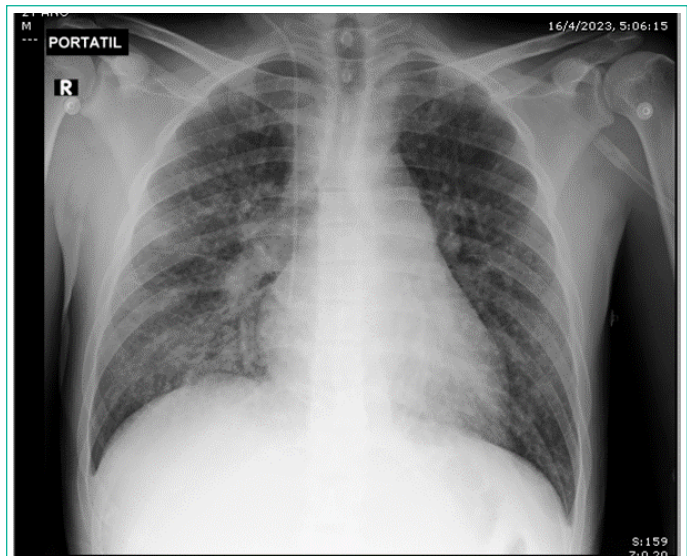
Chest x-ray upon admission to the ICU.
